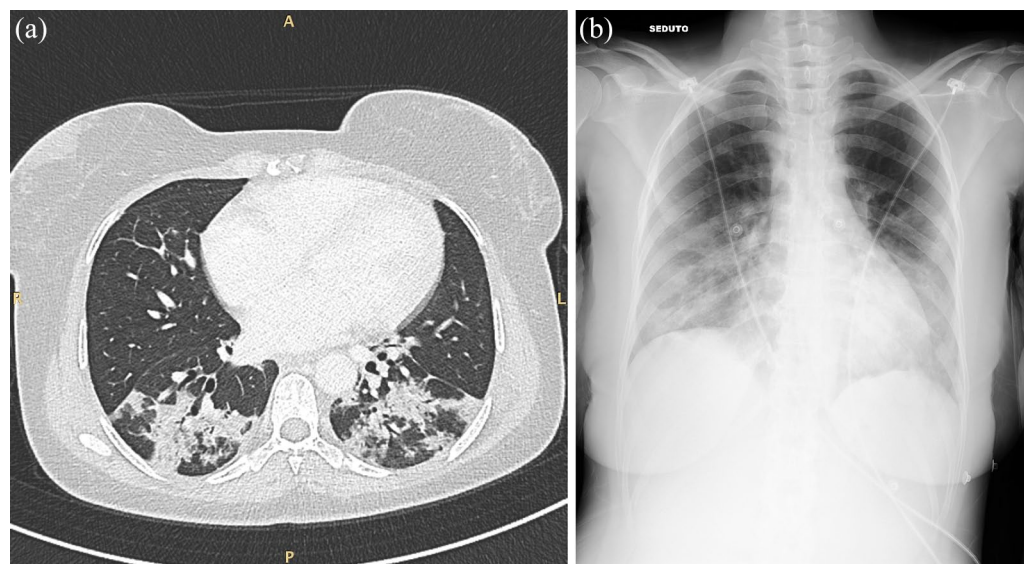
Diffuse ground glass opacities, air-bronchogram images, and bilateral pleural effusion on high-resolution computed tomography in a patient with hemorrhagic alveolitis in systemic lupus erythematosus before (a) and after (b) methylprednisolone pulses and high-dose intravenous glucocorticoid therapy.
